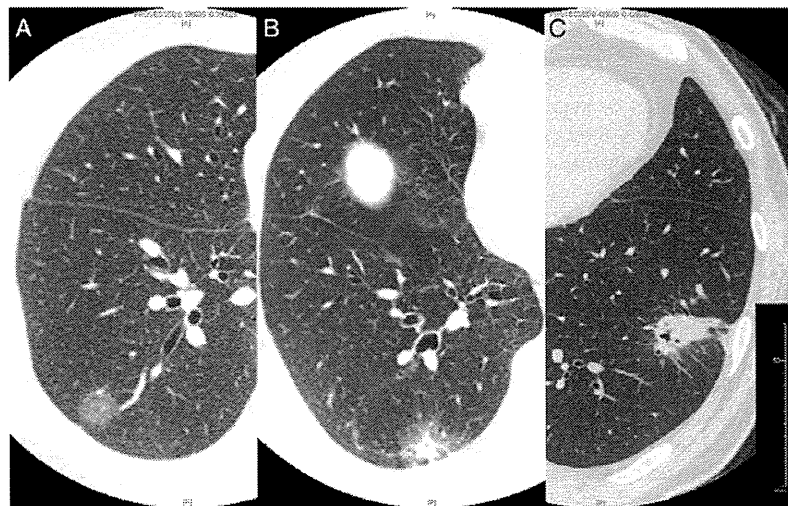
Representative appearances of pure GGO lesion (A), GGO with solid component lesion (B) and pure solid lesion (C) in thin-sliced CT. Whole size of the lesion is 1.8 cm in (A), 2.8 cm in (B) and 2.8 cm in (C), and size of the solid component is 0 cm in (A), 1.5 cm in (B) and 2.8 cm in (C).
